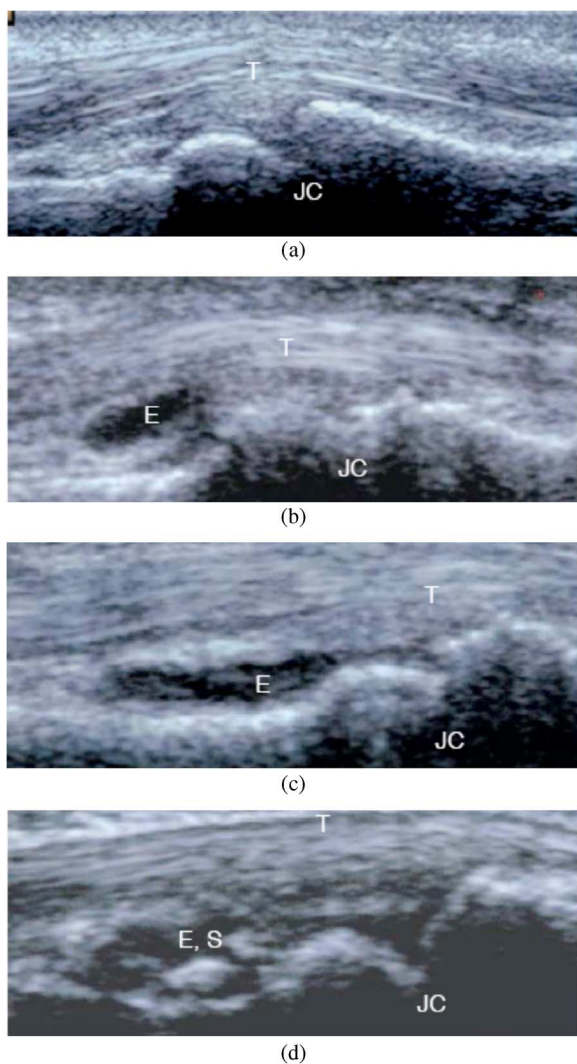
Ultrasound images of a healthy joint (a), and joints affected by RA (b), (c), (d). The larger the anechoic area and/or extent of synovial hypertrophy, the higher was the ultrasound score (USS) (USS = 1 minimal, USS = 2 moderate, USS = 3 extensive effusion/hypertrophy). Images were produced by placing a hockey stick linear array transducer on the palmar side of the PIP joint. (E = effusion, S = synovitis, T = tendon, JC = joint cavity).
